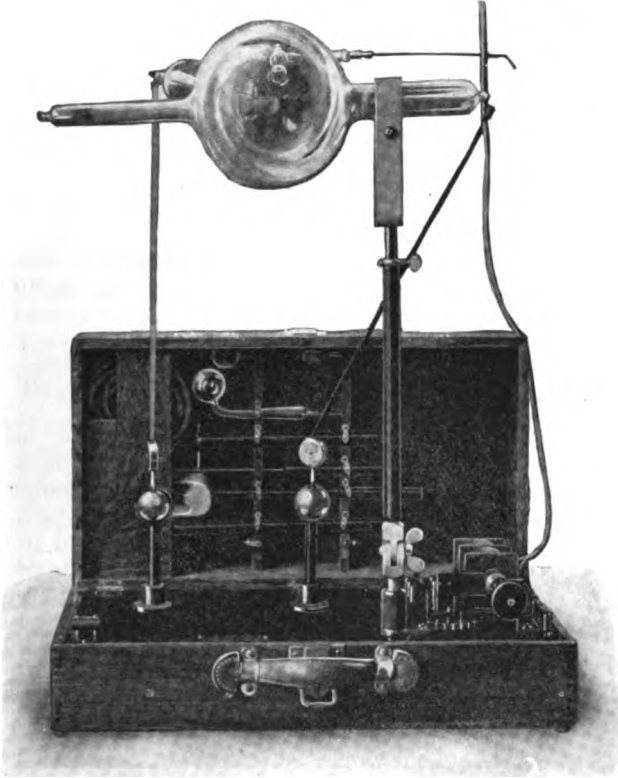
Portable *x-ray* and high-frequency apparatus of the Tesla type (Hyfrex No. 1).
